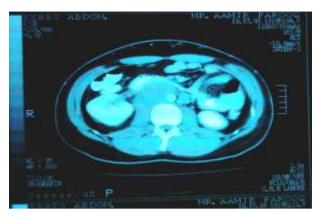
CT Scan Abdomen- Paraortic and paracaval lymphadenopathy
